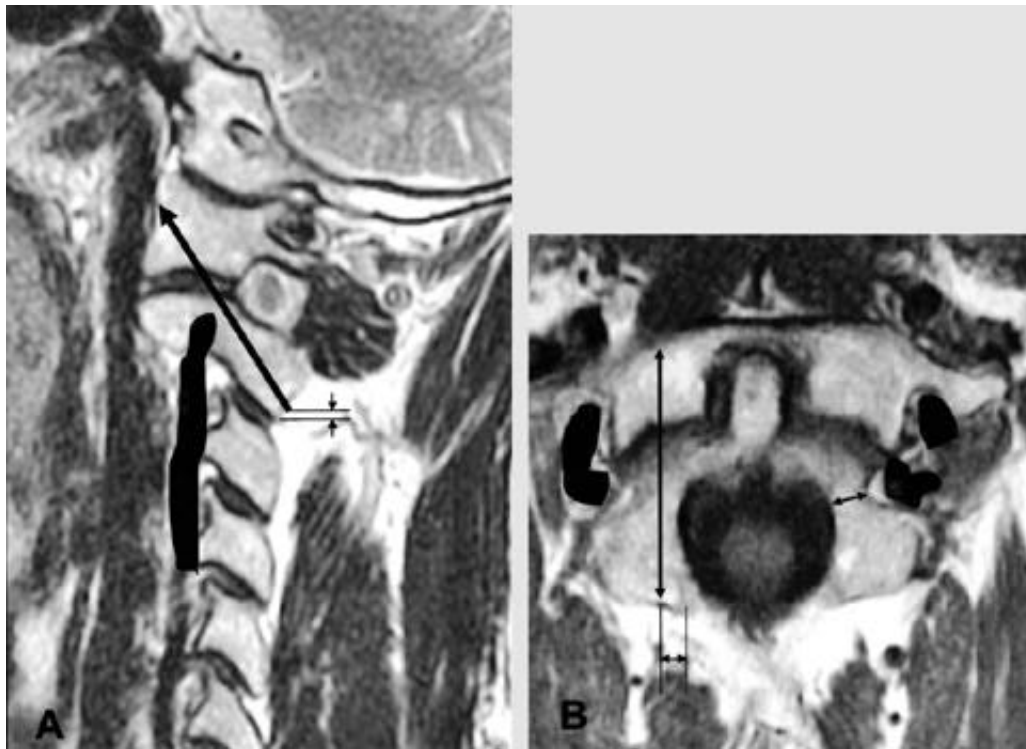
Ideal entry points, insertion angle and length of the C1-2 transarticular screw were on the sagittal and oblique axial MR images using PACS digital measuring instrument.
